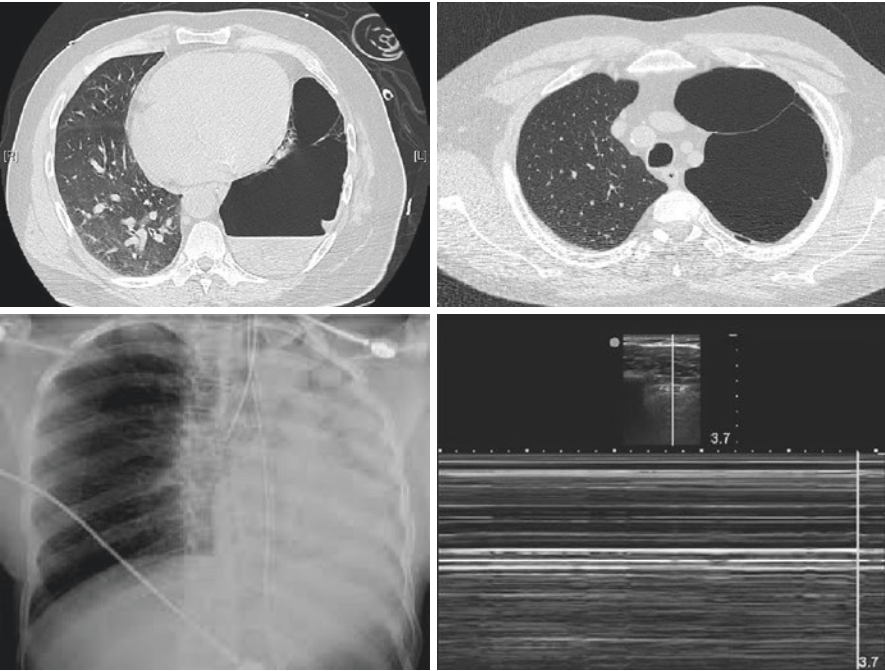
Pneumothorax mimickers on ultrasonography. All may present with lack of lung sliding
